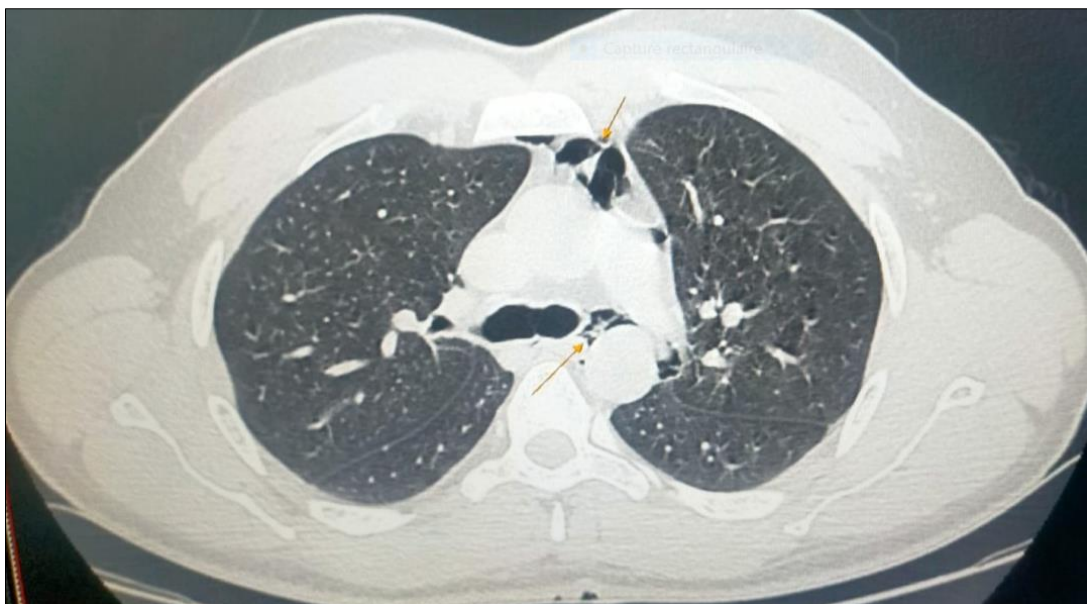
CT scan confirmed the pneumomediastinum with the presence of radiological signs in favour of Boerhaave syndrome.
